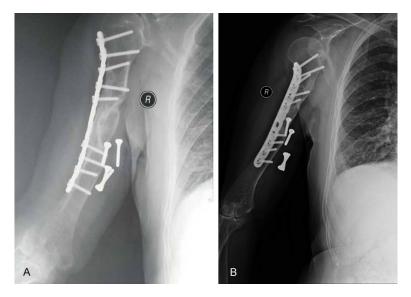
Clinical follow-up at 27 months after nonunion repair. Anteroposterior (A) and lateral (B) radiographs showing the fracture healed and cortical graft seems to be completely integrated.
